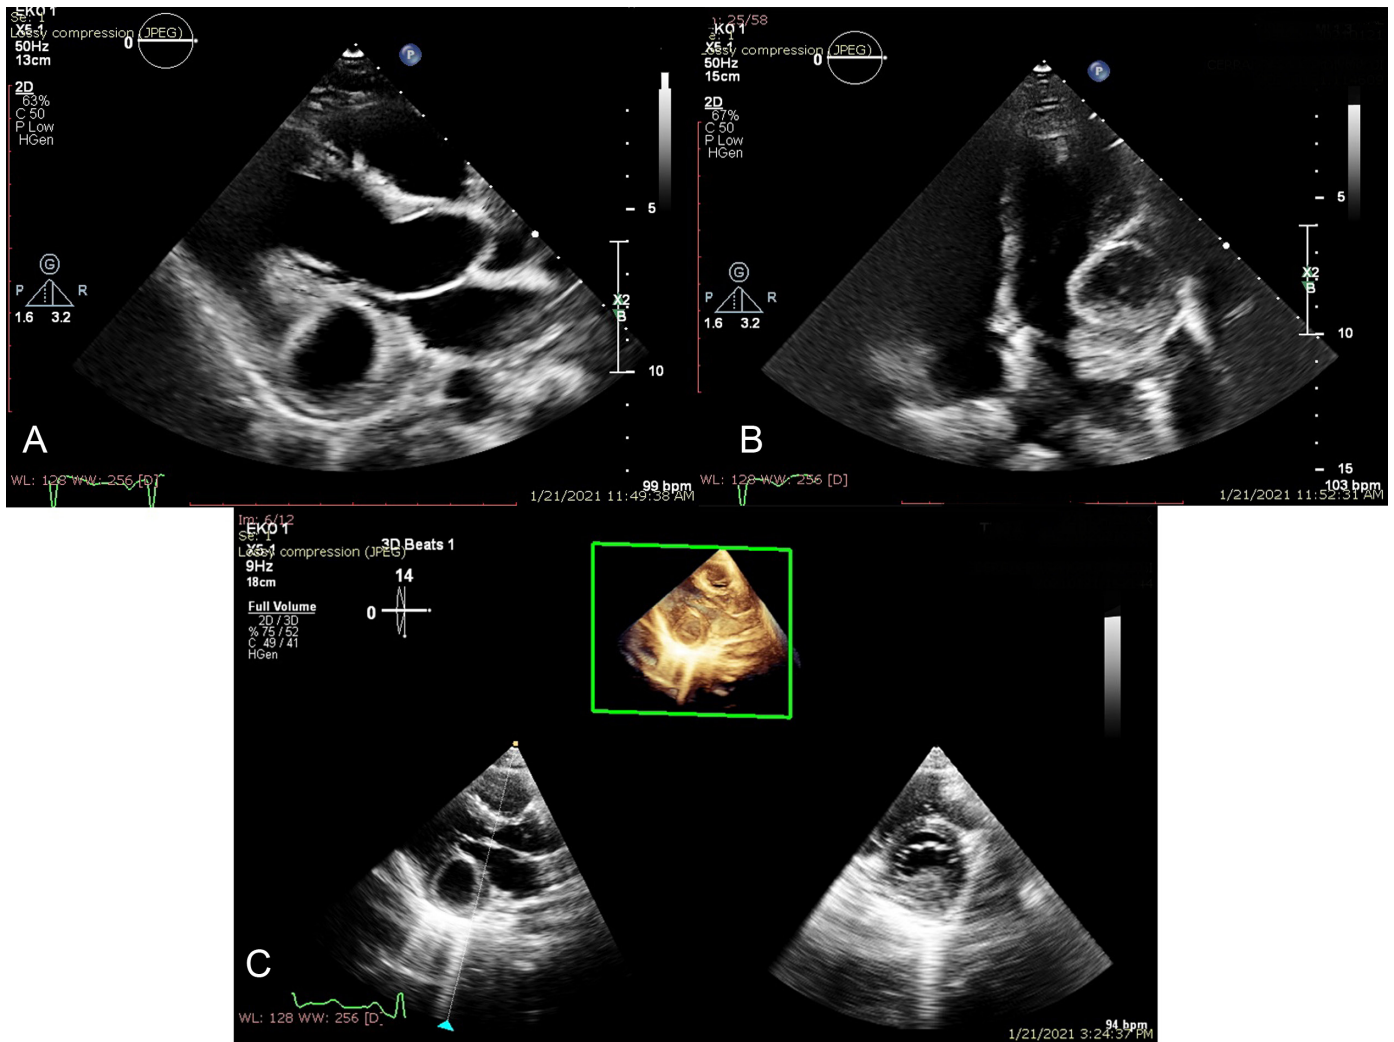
A-C. Echocardiographic imaging of the cyst hydatid. (A) PLAX orientation shows the cystic structure located in posterobasal segment of the LV. (B) A4C orientation. (C) cystic structure imaging by using 3D full volume sequence. A4C, apical 4 chamber; PLAX, parasternal long axis; LV, left ventricle; 3D, 3 dimensional.
